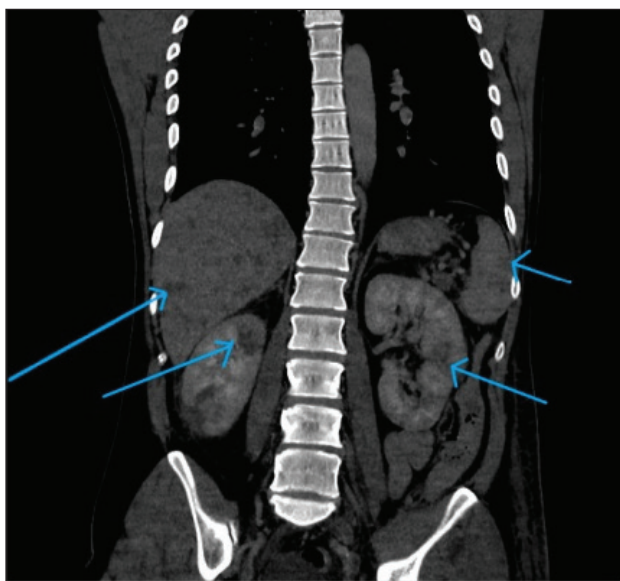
CT of the chest, abdomen and pelvis with contrast: Multiple liver metastasis without obvious primary tumor, bilateral kidney infarcts and splenic infarcts, bilateral small pulmonary embolism in both lower lobes. 188 × 166 mm (96 × 96 DPI).
